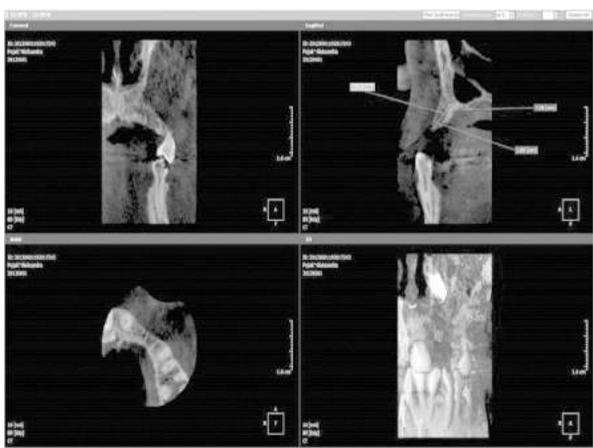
Control CBCT scan
